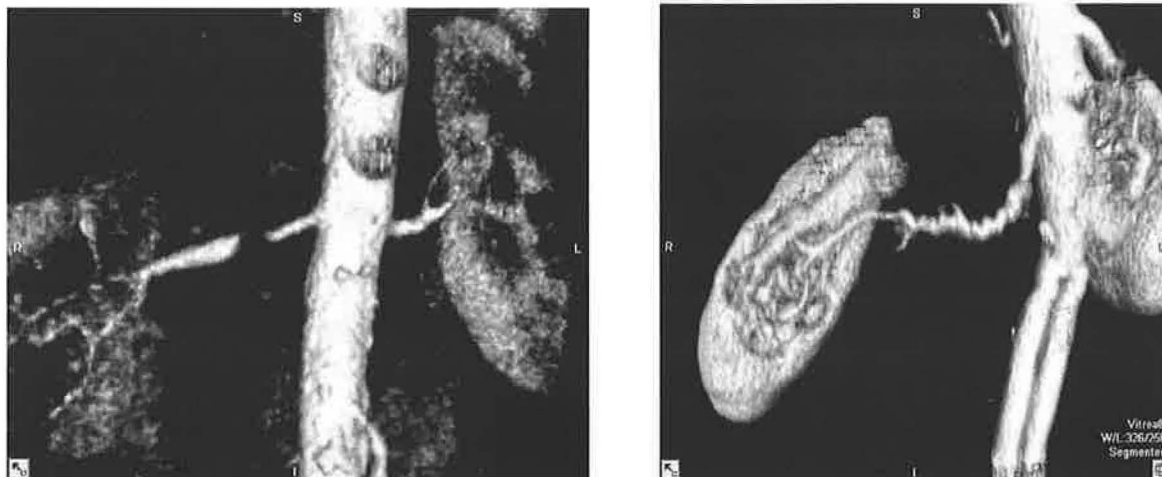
CT angiography images from 16-row scanners showing severe atherosclerotic renal artery stenosis (left panel) and fibromuscular dysplasia of the right renal artery (right panel). Image courtesy of Dr. Bart Dolmatch, Department of Radiology, UTSW.
